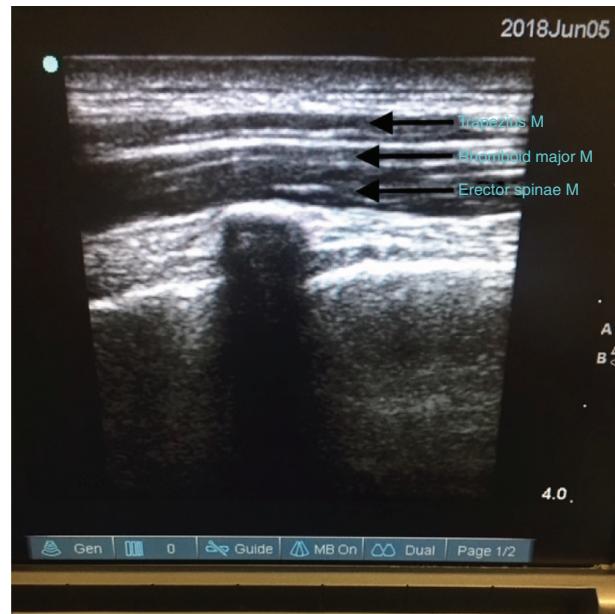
High-frequency ultrasound probe in longitudinal orientation.
